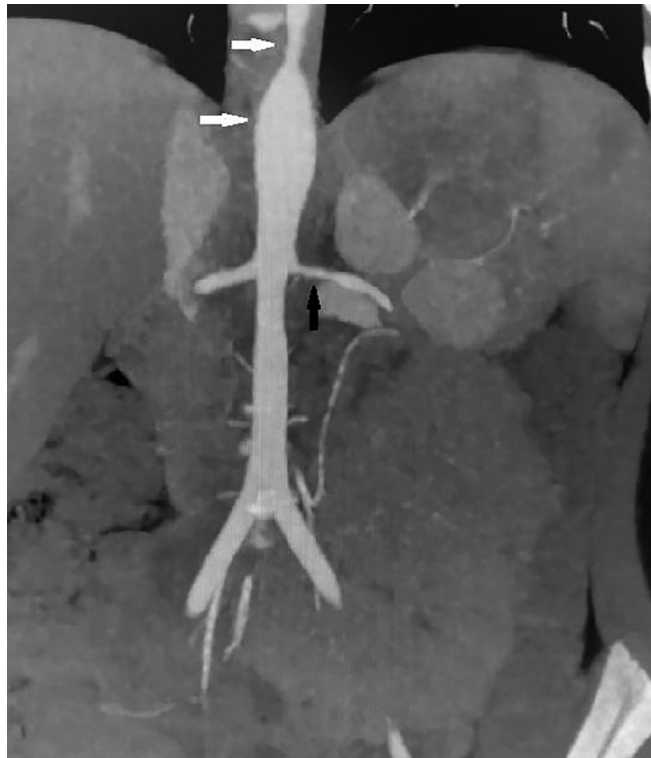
Computed tomography examination of an 8.5-year-old girl with Takayasu arteritis, revealing arteritis of the aortic arch and the branching arteries. Characteristics identified include increased wall thickness extending from the thoracic aorta to the abdominal aorta leading to an aneurysmatic appearance and slight narrowing in the lumen (white arrows) and the narrowed orifice of the left renal artery, with enlargement and blurring of the walls (black arrow).
